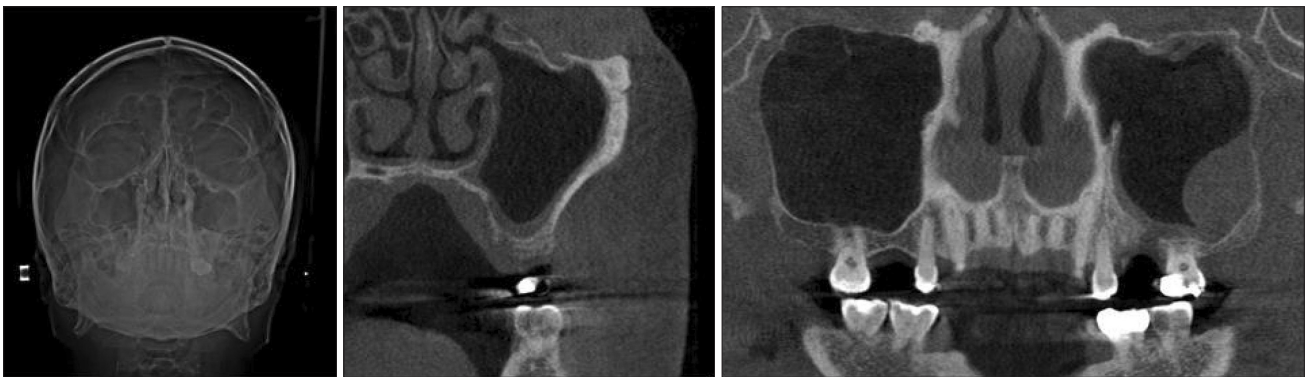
Radiograph 1 month after extraction of #26. The radiolucency in the left maxillary sinus has nearly resolved.
